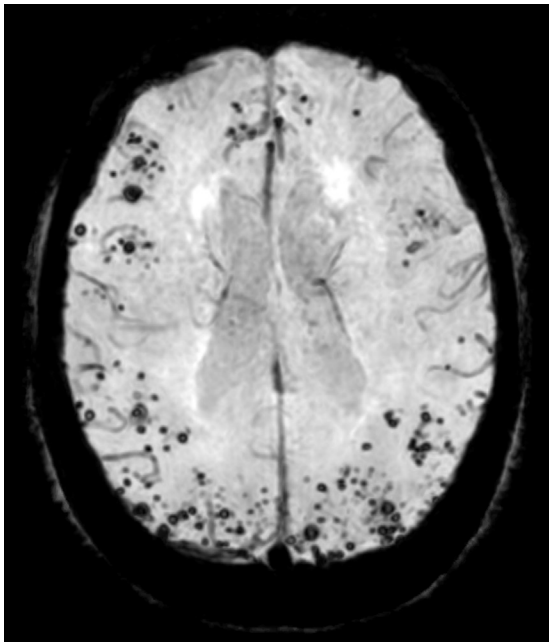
A 79-year-old woman underwent high-field MRI with susceptibility-weighted sequence, which revealed multiple microhemorrhages secondary to amyloid angiopathy. This can lead to lobar intracerebral hemorrhage in elderly patients.
